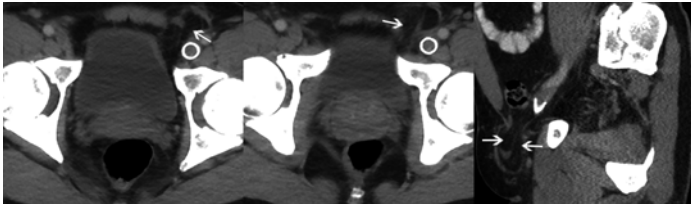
Axial and sagittal CT images acquired through the pelvis in a patient with a pair of unilateral direct hernias (*white arrows*). While these hernias were clearly palpable on physical exam, smaller defects may require MR for detection.
